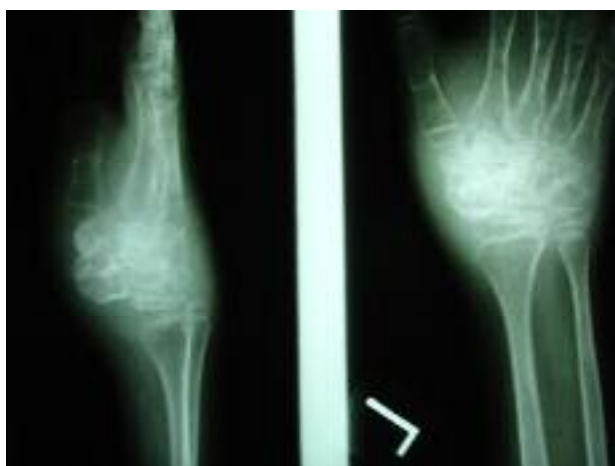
Preoperative X-ray two years after first X-ray
